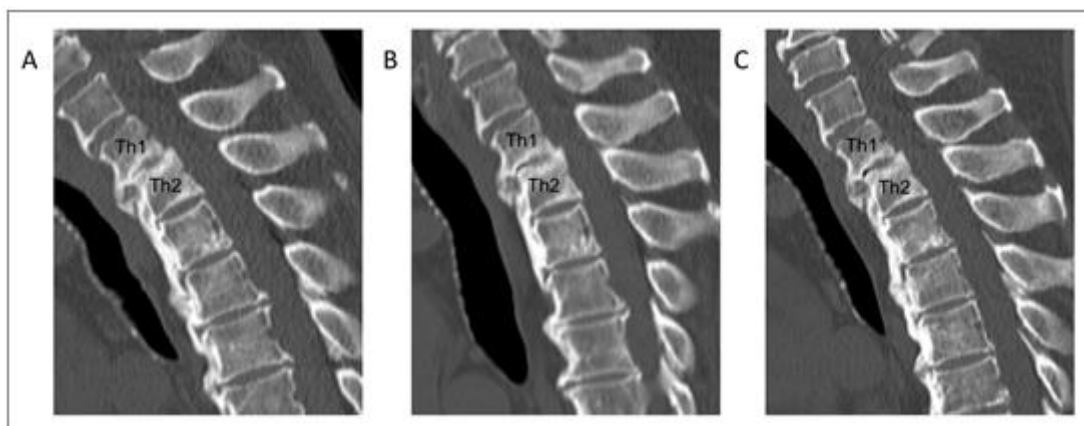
Dynamic CT imaging of the thoracic spine.
